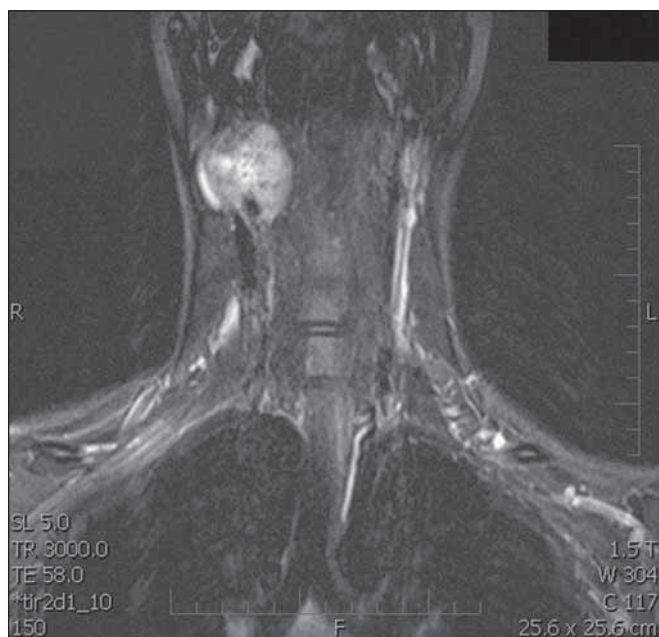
T1-weighted MRI scan, after administration of gadolinium, demonstrates a mass within the right carotid space. Both the external carotid artery and the internal carotid artery are constricted.
